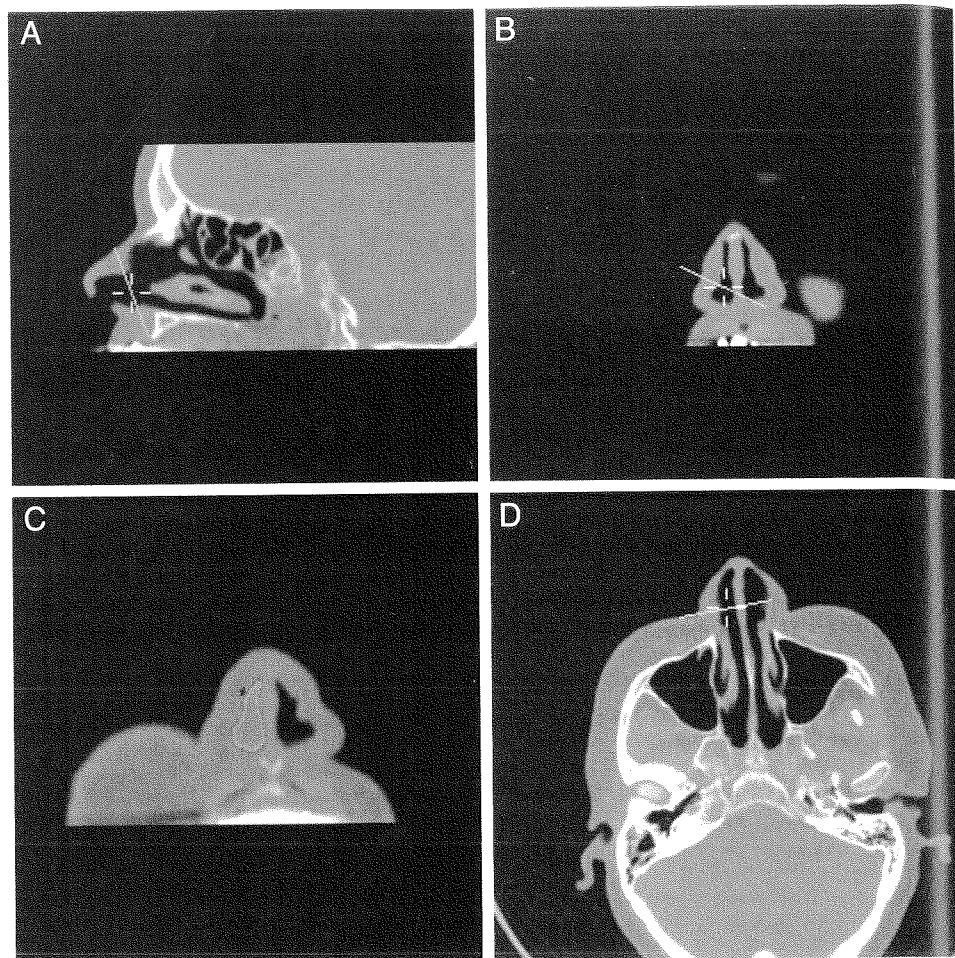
Views of the computed tomography scan presented by the software. The yellow cross-hair indicates the selected location corresponding in all three views. The green line indicates the intersection of the oblique slice plane with the orthogonal views. (A) The sagittal slice plane. (B) The coronal plane. (D) The axial plane. (C) The oblique slice plane with the determined area of the nasal passage in white.
